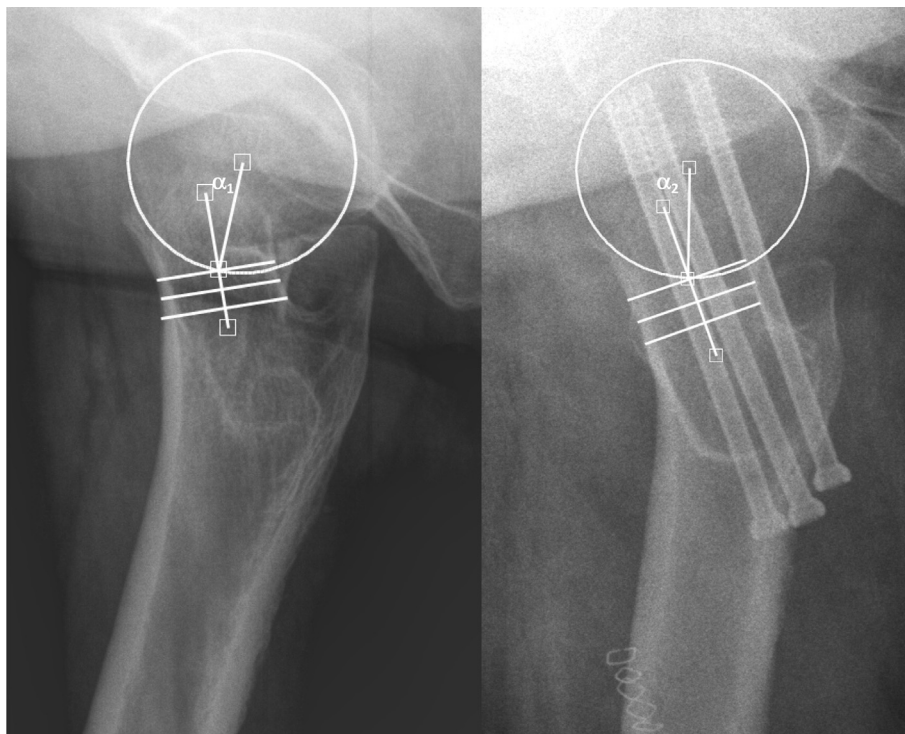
Preoperative and postoperative shoot through lateral radiographs presenting posterior tilt measurements on a patient who underwent a later conversion to arthroplasty at 4 months. α_1 , 22.6°; α_2 , 20.0°.
